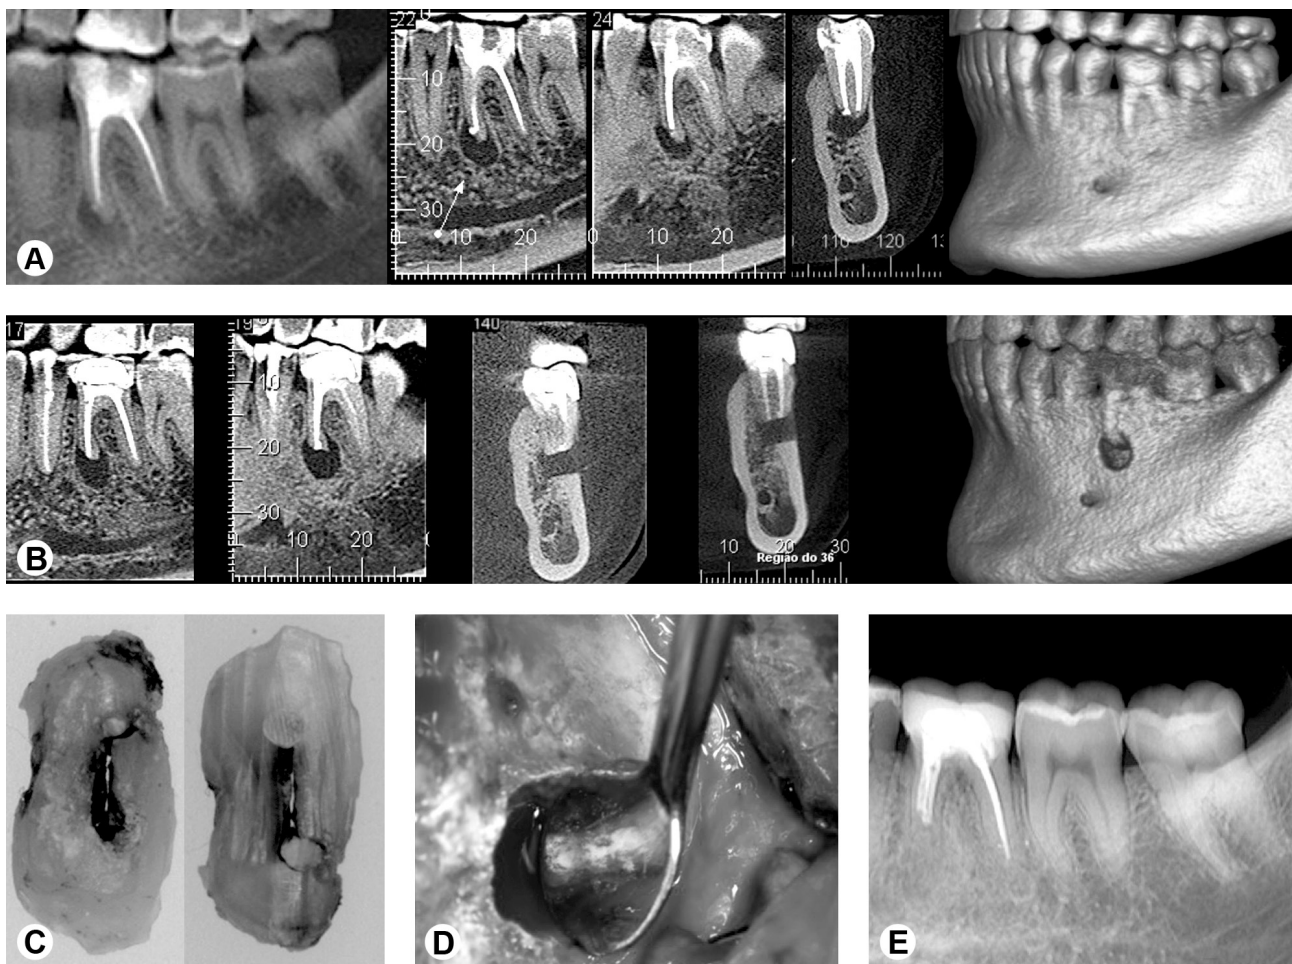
(A-E) - CBCT scans show first mandibular molar right that due persistence of infection was detected failure of retreatment (A). After 24 months follow-up of the periapical surgical, and due to maintenance of AP (B), a new surgical reintervention was proposed. In this moment, it was observed area of the isthmus (C). After removing of the apical root-end and the periapical lesion, and filling the isthmus area with MTA (D), the surgical cavity was filled with biomaterial (Bio-Oss®). In the new follow-up was observed healing in process of AP (E).
